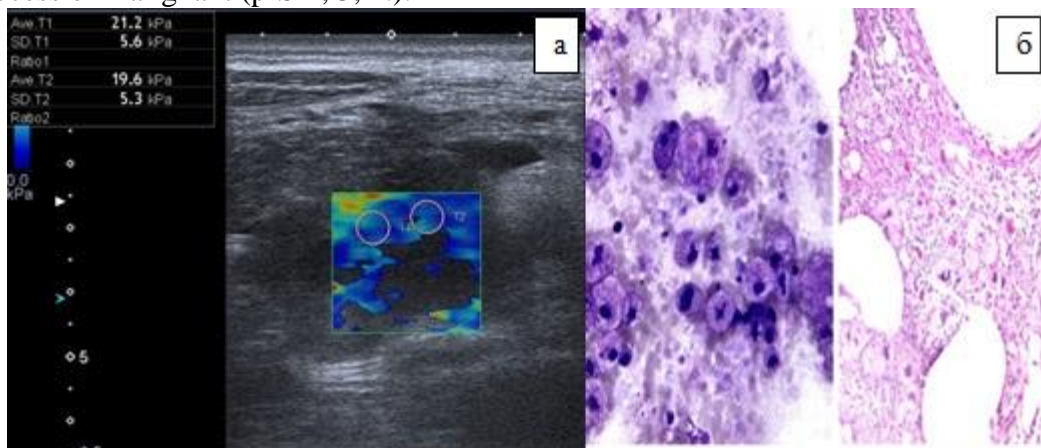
Pseudocyst of the pancreas. a — ultrasound scanning, elastography. b — microphotopreparation (increase $\times 40$)
